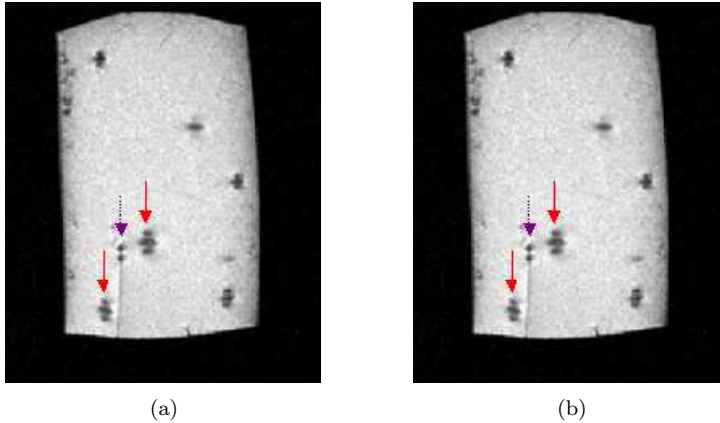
MR images of a piece of cheese (a) with the robotic device outside the MRI scanner room and (b) with the robotic device inside the MRI scanner
